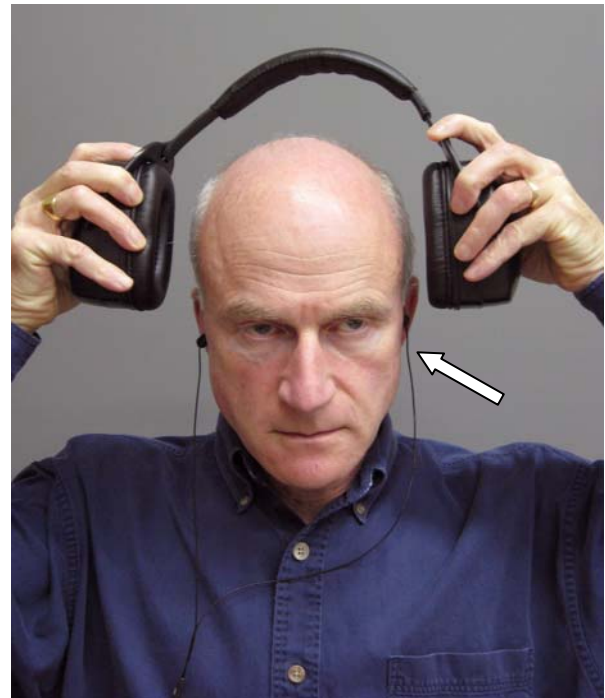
Doppler returns are best heard using in-ear ear buds or CEPs combined with a circum-aural hearing protector or a helmet with integrated hearing protection.
